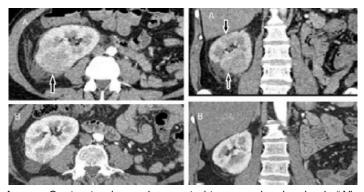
Contrast-enhanced computed tomography showing in "A" a wedge-shaped lesion with decreased enhancement (arrows), and in "B" marked improvement after three weeks of antibiotics.
